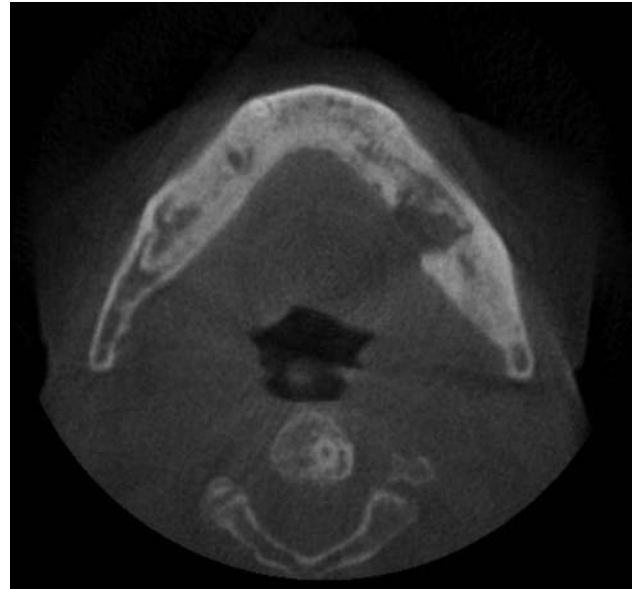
Axial cone-beam CT of the mandible shows extensive sclerosis, mottling, cortical destruction and sequestra formation.
